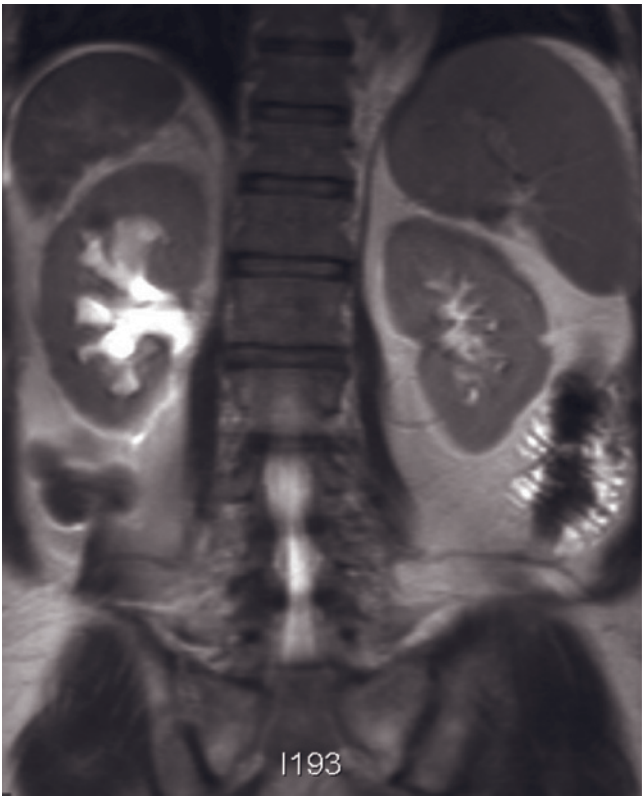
Cystitis cystica and pelvic lipomatosis. T1-weighted SGE (a) and 90-s postgadolinium fat-suppressed SGE (b) images. Note that the bladder wall is uniformly thickened (short arrows) and the distal ureters are thick walled and substantially dilated (long arrows). Coronal T2-weighted single-shot echo-train spin-echo (c), coronal T1-weighted SGE (d), and coronal
